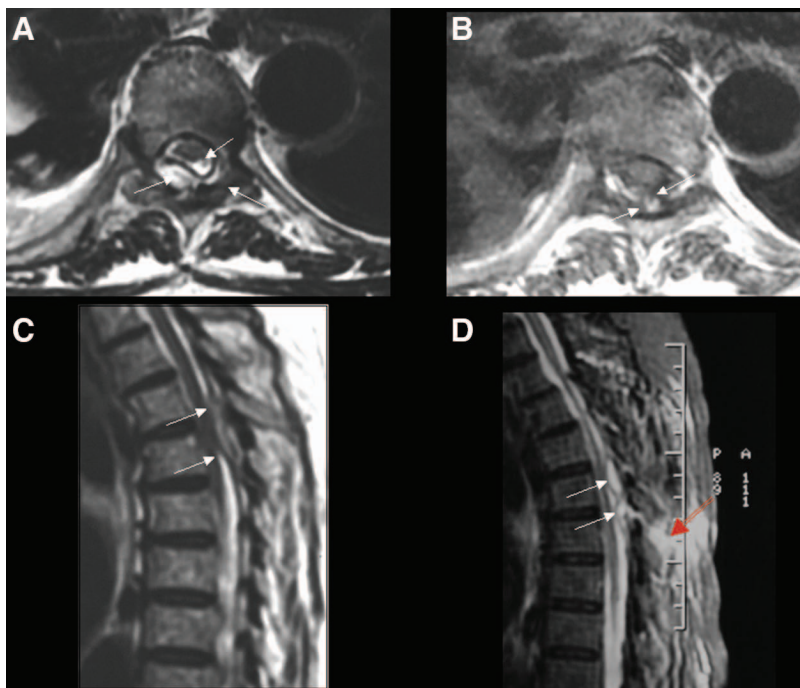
T2- (A) and T1- (B) weighted axial and sagittal T2WI magnetic resonance imaging (C) showing an epidural abscess (white arrows) from the 4th to 6th thoracic vertebral levels with no evidence of spinal cord compression. Linear hyperintense signal in short T1 inversion recovery (STIR) sagittal image compatible with fistulous tract (D) in 5th to 6th interspinous space (red arrow).
